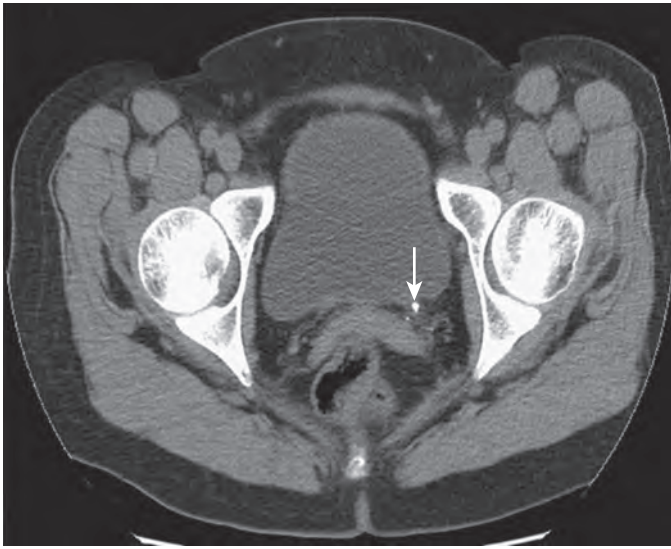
Ureterolithiasis: CT features. A 2-mm stone (arrow) is lodged at the left ureteropelvic junction.
